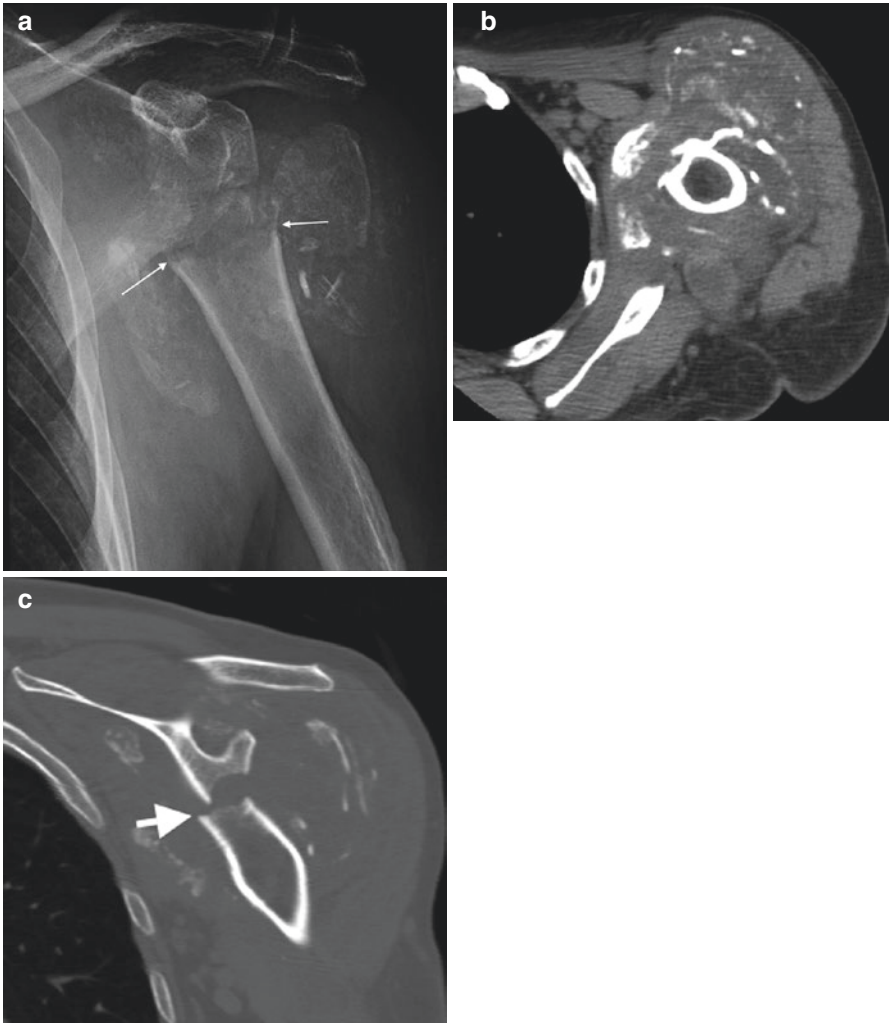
Neuropathic arthropathy of the shoulder on (a) AP radiograph demonstrating diffuse soft tissue and joint swelling, multiple fractures with variable degree of osteolysis of bone fragments, bony debris, disorganization and dislocation without increased density in keeping with an atrophic neuropathic type joint. Note the straight
